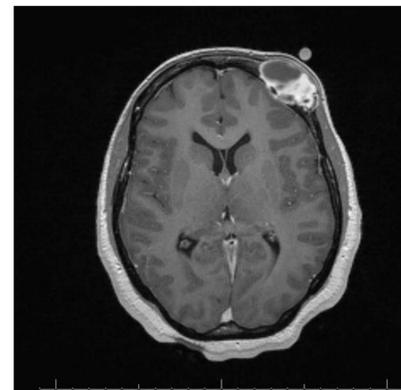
Axial T1 brain MRI with post gadolinium administration demonstrating a heterogeneously enhancing diploic space lesion.
